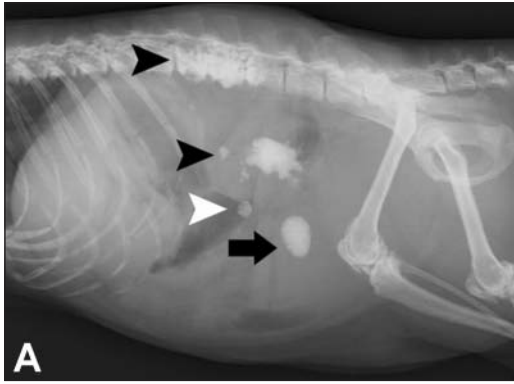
Same radiographic views as in Figure 1. Notice the large accumulations of mineral opacities in both renal pelvises extending into the pelvic recesses (black arrowheads) and a single large calculus in the urinary bladder (arrow). There is a small round mineral opacity in the gastrointestinal tract (white arrowhead).
